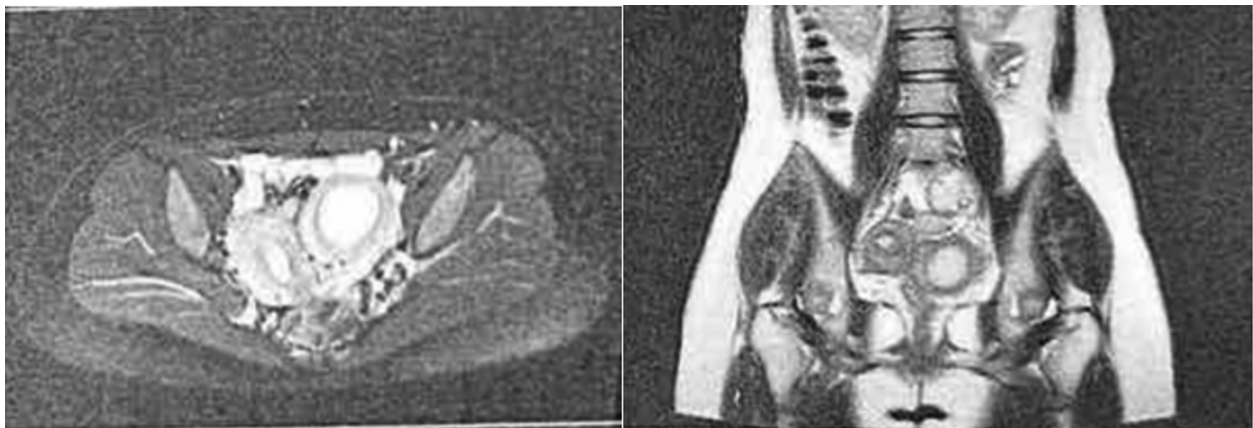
MRI images which revealed a pedunculated pelvic mass exhibiting peripheral signals similar to the myometrium arising from the left side of the uterine fundus.
